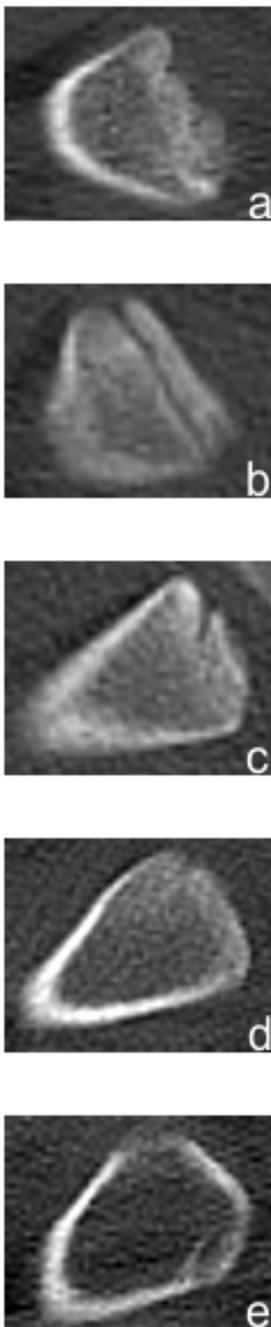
CT scan images of the ossification status of medial clavicular epiphyseal cartilage:
